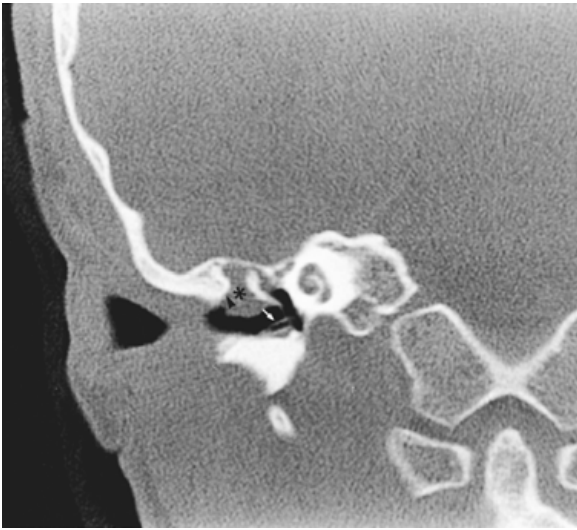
Attic cholesteatoma, coronal computed tomography. There is a bulky soft tissue mass in Prussak's space (asterisk). The scutum (arrowhead) and lateral short process of malleus are eroded. Prussak's space is widened, and the malleus is displaced medially. A tympanostomy tube is in place (white arrow). Note the normal extension of the osseous spiral lamina into the apex of the cochlea.
